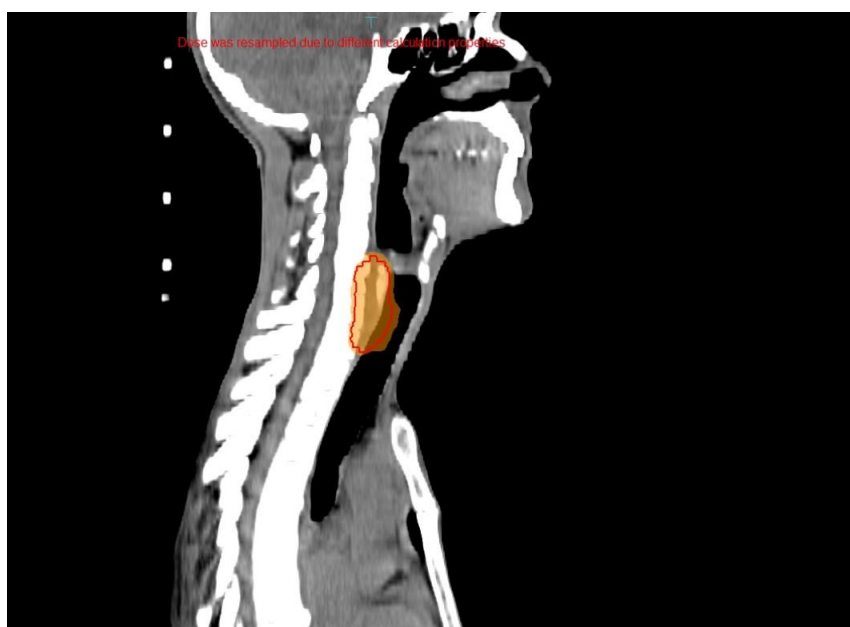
Radiotherapy isodose curve (sagittal view): the planning CT scan with 66 Gy (in orange) isodose lines
